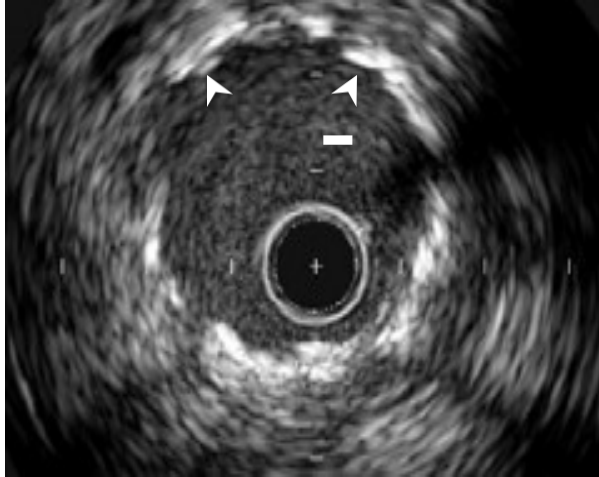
Intravascular ultrasound (IVUS) post-implantation of a BRS in a patient with severe stenosis of mid left anterior descending artery (same patient shown in Figure 18, p. 84) Adequate strut apposition is shown (arrows). Stent struts are usually moderately visible in IVUS, as seen here. Copyright © 2016 Samer Mansour.
